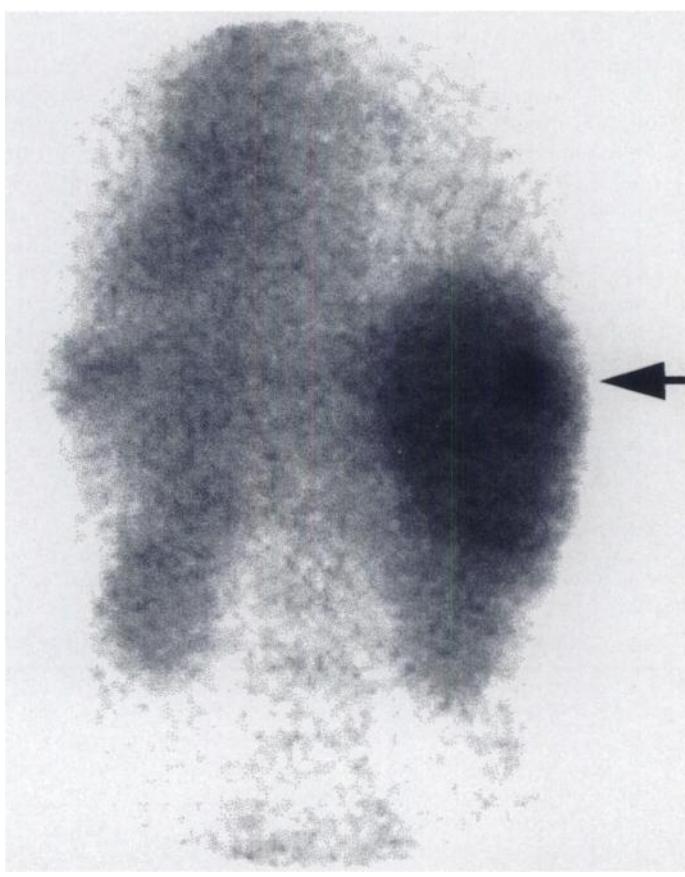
Planar scintigraphy (posterior view) of abdomen of Patient 28 who had no tumor site known before IS. Liver hot spot (arrow) was visualized and later confirmed by IS-directed MRI. IS also detected cervical recurrences that were removed surgically (not shown).
